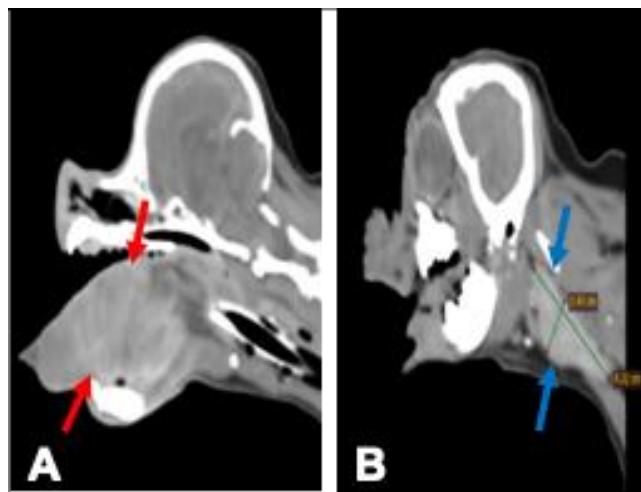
Sagittal CT images showing a lingual mass (A, red arrows) and left medial retropharyngeal LN (B, blue arrows). (A) Ill-margined, heterogeneously hyperattenuated, thickened mass is found in the tongue. (B) Enlarged and elongated Lt. medial retropharyngeal LN with contrast enhancement.
